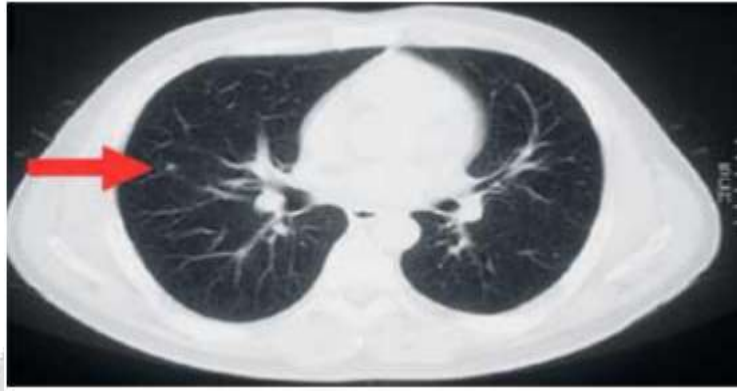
CT Scan slice at an early-stage of lung cancer
